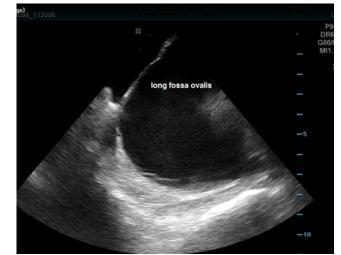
Intracardiac echocardiography to guide transseptal puncture. This septum has a different structure compared to the previous. It is thinner with a long fossa ovalis.
